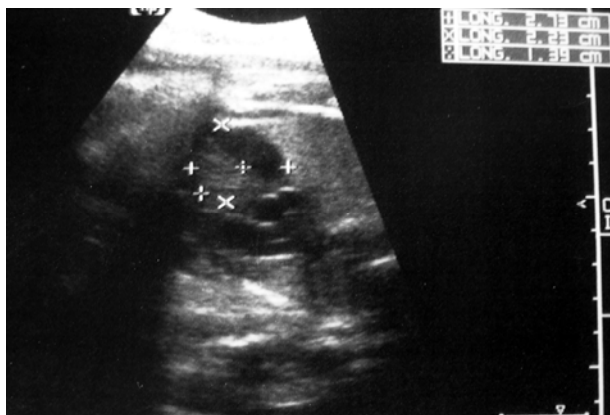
Sonography at 34 weeks' gestation with a 27 × 23 mm heterogeneous right anterior mediastinal cyst.
